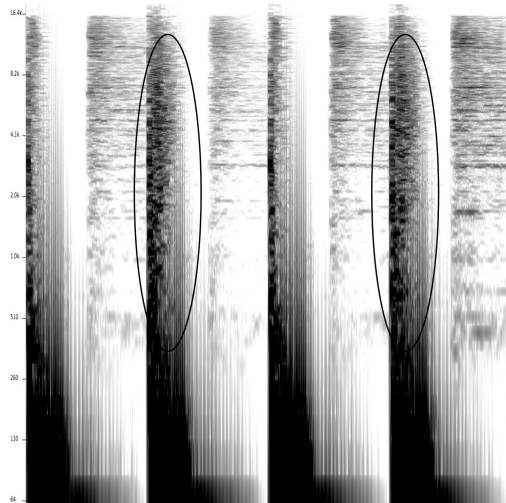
Sonogram of Hercules and Love Affair, *Blind* (Frankie Knuckles Remix), 0:05–0:07. Snare drums circled.
